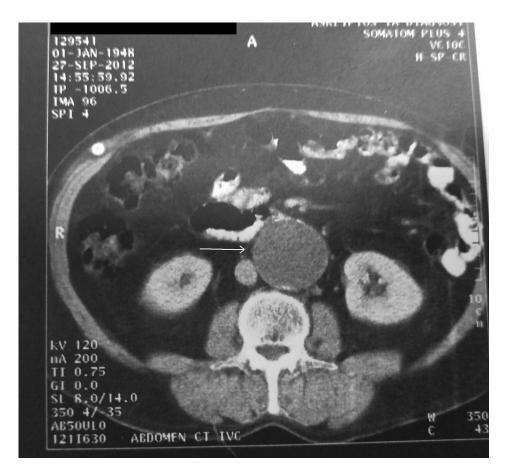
Computed tomography angiography (CTA) showing a totally thrombosed abdominal aortic aneurysm (AAA, *arrow*) presented 5 years ago.
